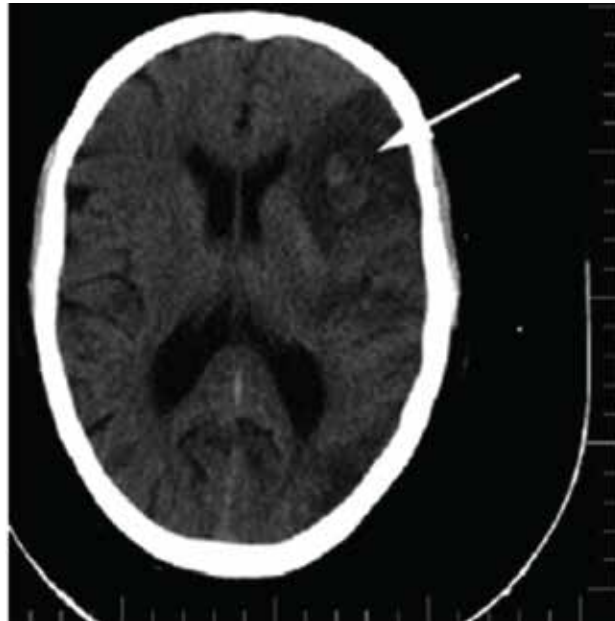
ASPECTS on this slice count to 6, however further slices are needed for complete quantification¹⁵.
